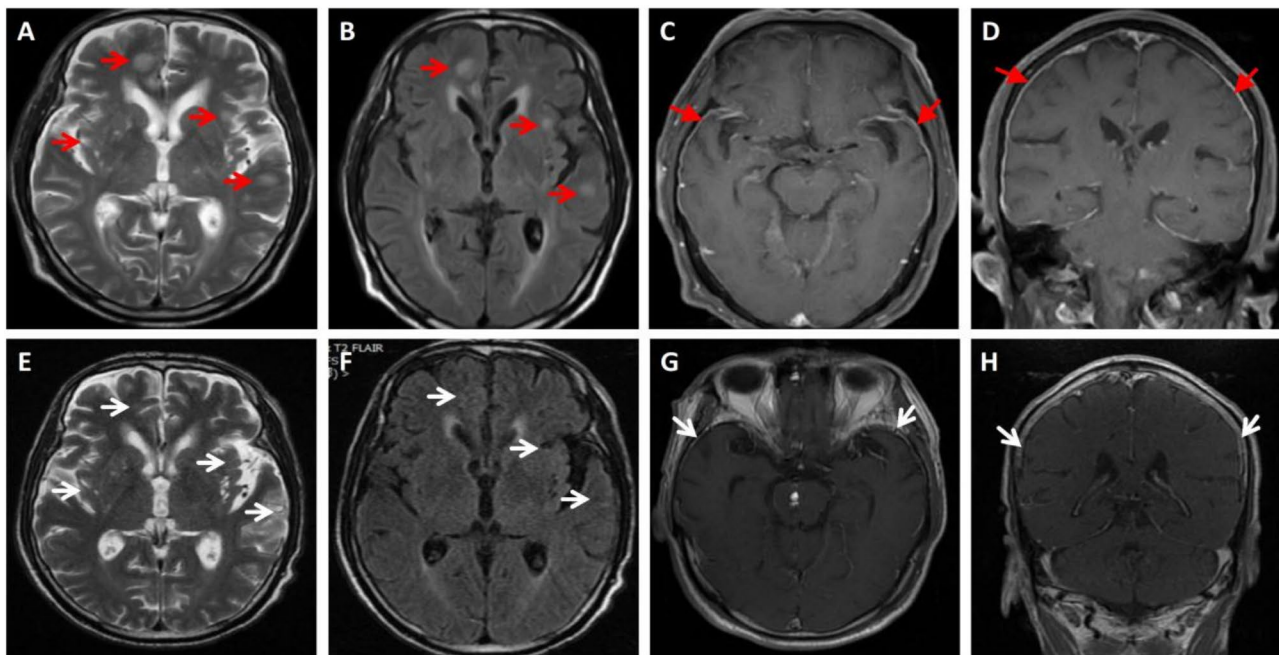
A-D: The brain MRI scan revealed small, patchy abnormal signal foci located in the bilateral basal ganglia, frontal and parietal lobes, and periventricular regions. These foci exhibited high signal intensity on T2-weighted and FLAIR imaging. Post-contrast enhancement demonstrated thickening and enhancement of the dura mater in the bilateral frontal regions. E-F: In comparison to the prior scan, the small patchy abnormal signal foci in the bilateral basal ganglia, frontal and parietal lobes, and periventricular regions have resolved. Additionally, post-contrast imaging reveals the absence of abnormal dural enhancement
